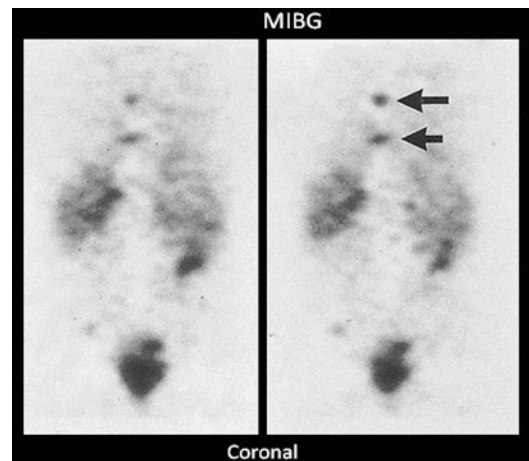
Representative coronal images from a SPECT ^{123}I -MIBG study for a patient with neuroblastoma, showing metastases to the spine (arrows)
